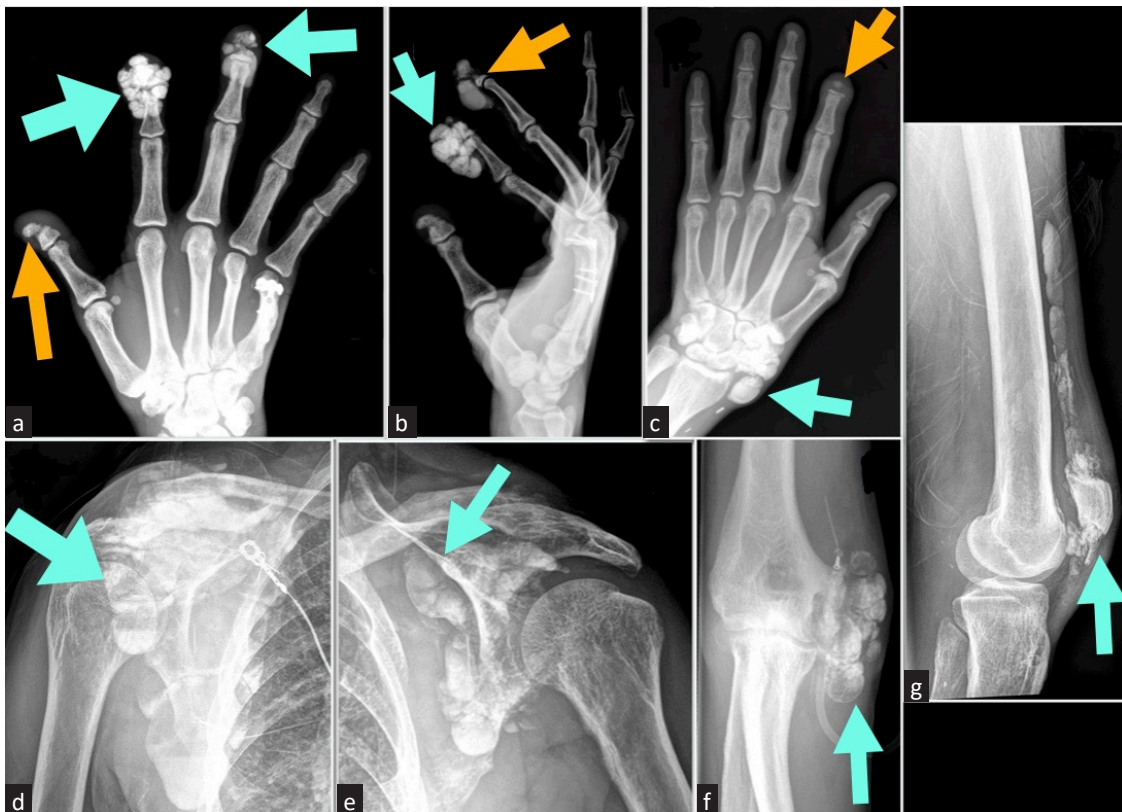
Plain radiograph showing calcified densities (blue arrows) in the (a and b) right index and middle fingers, (c) left wrist, (d and e) bilateral shoulders, (f) left elbow, and (g) left femur. Orange arrows represent acral osteolysis that affected the distal phalanx of (a) right thumb, (b) right long finger, and (c) left index finger.
